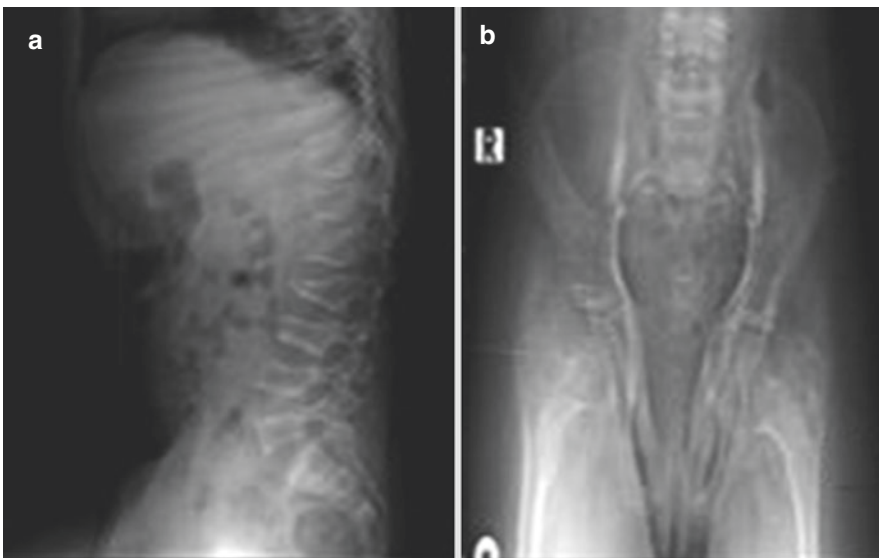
Osteogenesis imperfecta. (a) Lateral radiograph of the thoracolumbar spine shows osteopenia with thin cortices, codfish vertebrae in the lumbar spine, and compression fractures with anterior wedging involving
